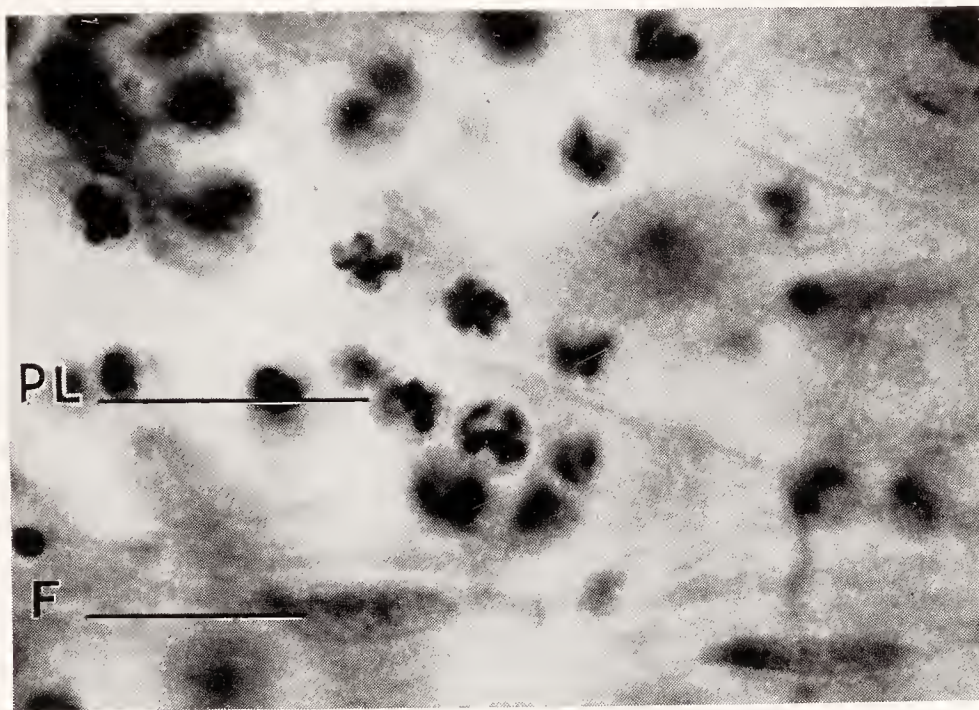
Typical cell forms in acute purulent inflammation of the periapical tissue. Infiltration of the connective tissue with polymorphonuclear leukocytes, *PL*, with round protoplasmic bodies and lobular nuclei; *F*, fibroblast.
